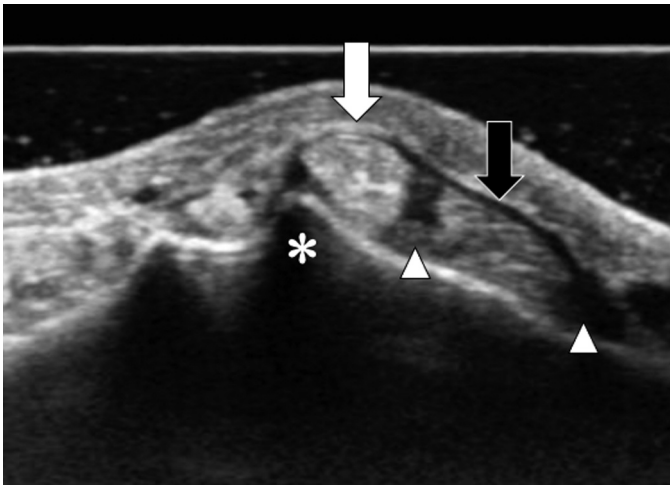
Ultrasonographic findings of case 1 (right: radial) at the patient's initial visit are shown. The ECRB tendon (white arrow) is elevated and extended over the Lister's tubercle (*) during active wrist extension. Mild hypertrophy of the synovium (high signal) and synovial fluid pooling (low signal) (arrowheads represent a signal change in the third compartment) around ECRB and extensor carpi radialis longus tendons (black arrow) are suspected.
